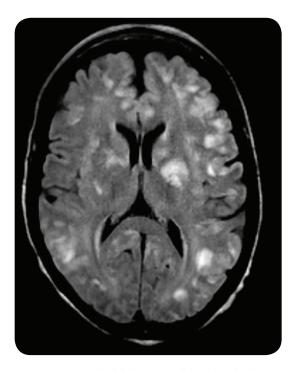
An MRI scan of the head of an individual with SLE who presented with altered mental status and seizures. There a numerous small infarcts suggestive of cerebral vasculitis. The individual improved after treatment with steroids.
